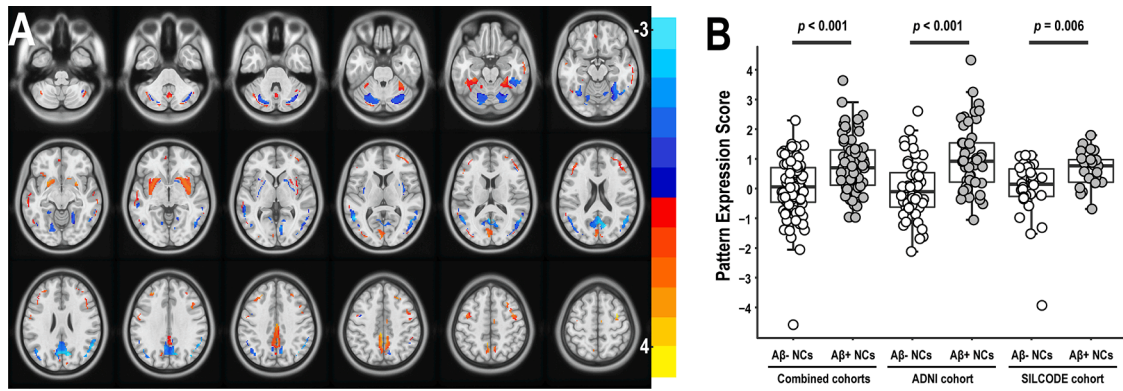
ARADRP identified by spatial covariance analysis of [¹⁸F]-FDG-PET scans from Aβ⁺ NCs and Aβ⁻ NCs in the combined cohorts. (A) Abnormal metabolic covariance topography in the ARADRP of the combined cohorts showing negative (cold color) and positive (warm color) regions coded by Z-scores. (B) Individual pattern expression score of the Aβ⁺ NCs and the Aβ⁻ NCs using the ARADRP identified from the combined cohorts. It should be noted that the scores are not absolute values, and the reference values used in the z-scoring are different between the combined cohorts and the independent cohort. Abbreviations: ADNI, Alzheimer's Disease Neuroimaging Initiative; SILCODE, Sino Longitudinal Study on Cognitive Decline; Aβ, β-amyloid; NCs, cognitively normal controls; ARADRP, at-risk Alzheimer's disease-related metabolic pattern; [¹⁸F]-FDG-PET, [¹⁸F]fluoro-2-deoxyglucose positron emission tomography.
